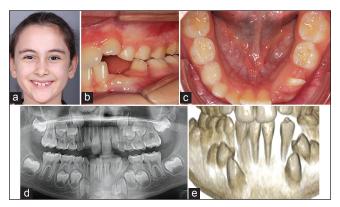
(a-e) Extra-oral/intraoral photographs and radiographs of the patient before orthodontic treatment
